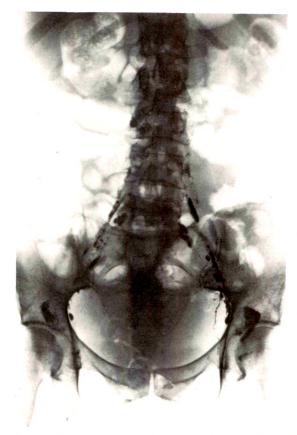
Postmortem roentgenogram of the paraaortic and para-iliac lymph node chains (see text).
